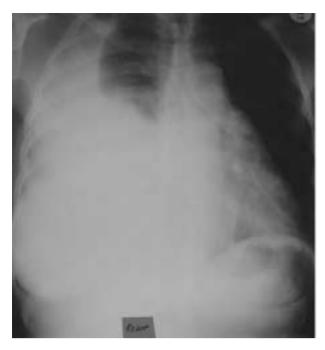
a and b. Consecutive chest radiographs of pleural effusion lymphoma after 4 cycles of CHOP, showing a complete respsonse.
